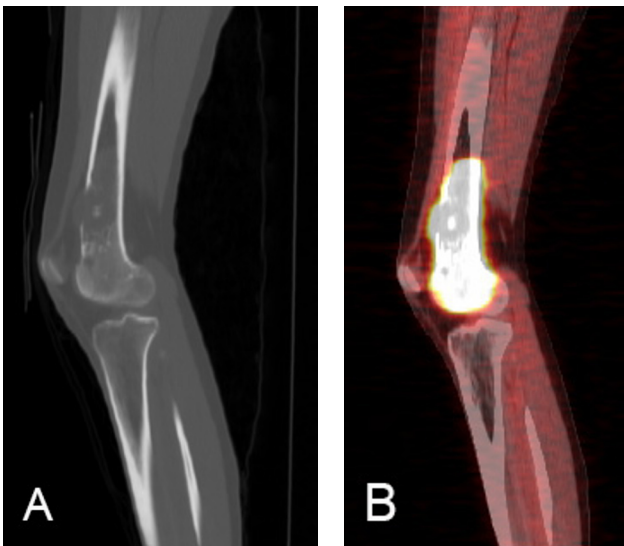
28-year-old female with left-knee pain. A. Sagittal computed tomography image demonstrated a lytic intramedullary lesion of the distal left femur with an anterior cortical breach. B. Sagittal positron emission tomography-computed tomography image demonstrated copious fluorodeoxyglucose avidity within the lytic intramedullary lesion of the distal left femur (maximum standardized uptake value measured 10.1).
